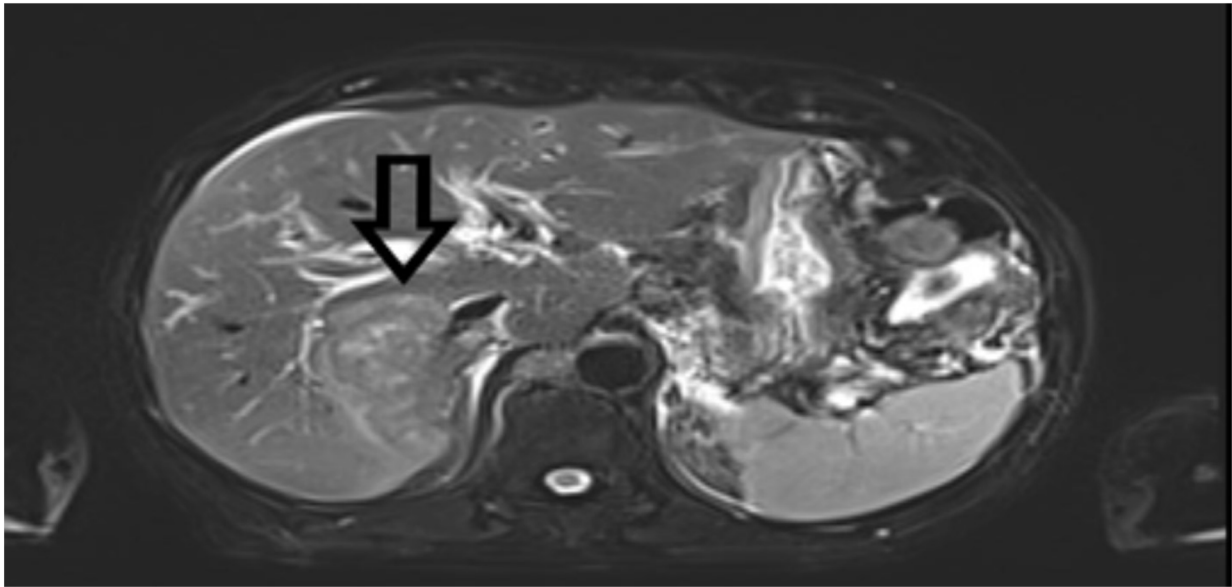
Magnetic resonance imaging of a metastatic lesion in the liver
